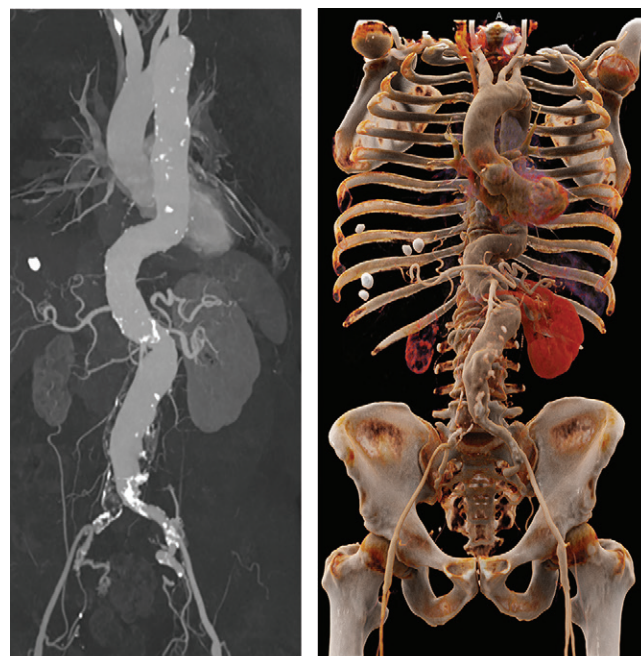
Images in a 63-year-old male study participant with untreated infrarenal aortic aneurysm. (a) Contrast material-enhanced CT angiography with individualized trigger delay in coronal maximum intensity projection after bone removal and (b) cinematic rendering. Stable attenuation along aortic and iliac path was rated as score 1 (excellent image quality) by both readers.
